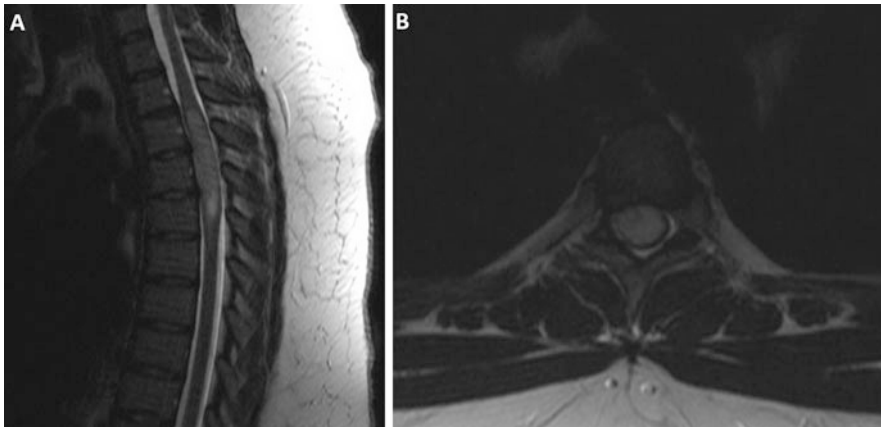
A 26-year-old female presented with a 2-year history of nonmechanical upper back pain and progressive BLE weakness. MR imaging (a and b) demonstrated a
